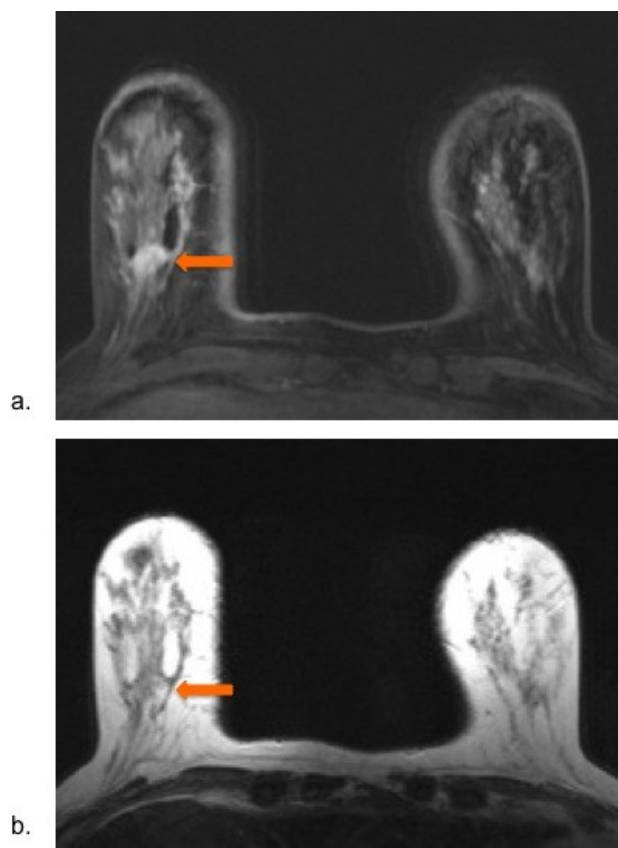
Breast MRI case
